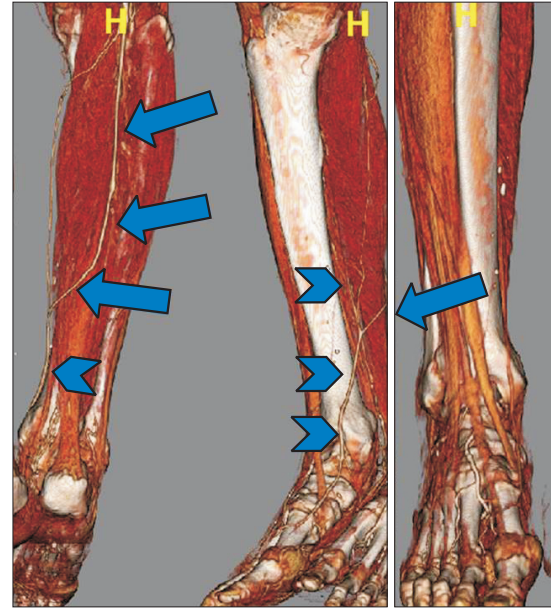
Three-dimensional computed tomography angiogram with volume rendering technique showing an unusual right small saphenous vein (arrows) connected with the great saphenous vein (arrowheads) at above the medial malleolus.
